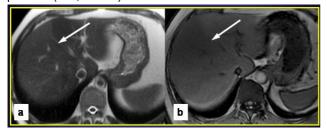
Chronic viral hepatitis. Axial T2-weighted HASTE image (a) and axial T1-weighted TurboFLASH image (b) show the equal contour and liver enlargement, diffuse-non-uniform signal intensity from liver parenchyma (arrow).
